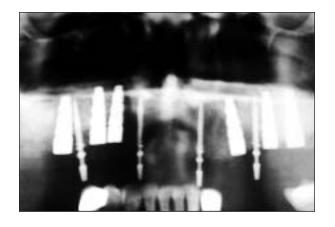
(*left*) Orthopantomogram shows unsplinted maxillary provisional implants.
